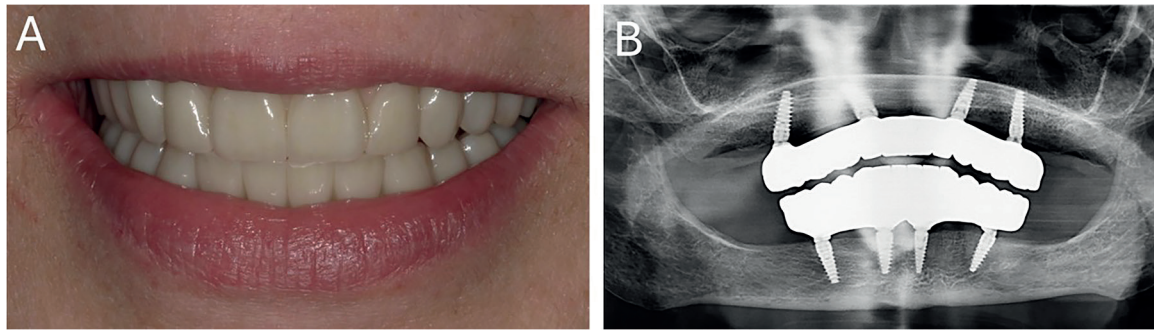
First case. Rehabilitation of the upper and lower jaws with two implant-supported full-arch fixed dental prostheses (ISFAFDPs). One year follow-up control. (A) Clinical picture of the final monolithic zirconia ISFAFDPs 1 year after the delivery, frontal view; (B) Panoramic radiograph 1 year after the delivery of the final ISFAFDPs.
